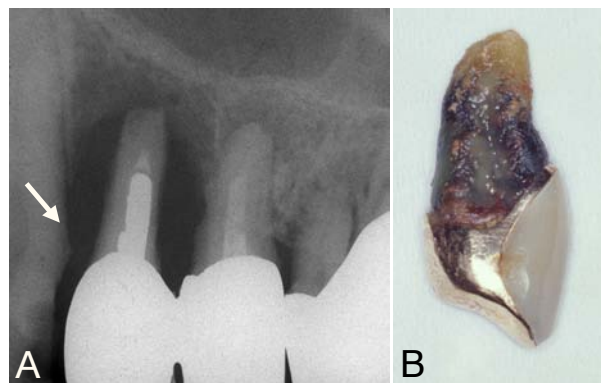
A: Dental radiograph of nearly eliminated tooth (arrow); B: Same tooth after extraction exhibiting remarkable darkened part.
